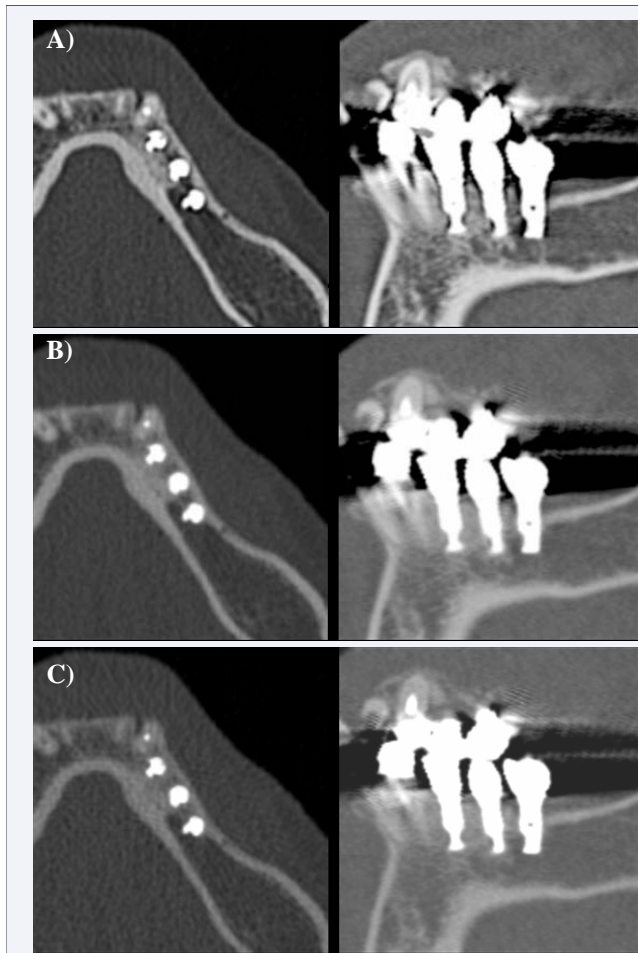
Three unique CT reconstructions using identical data sets.
